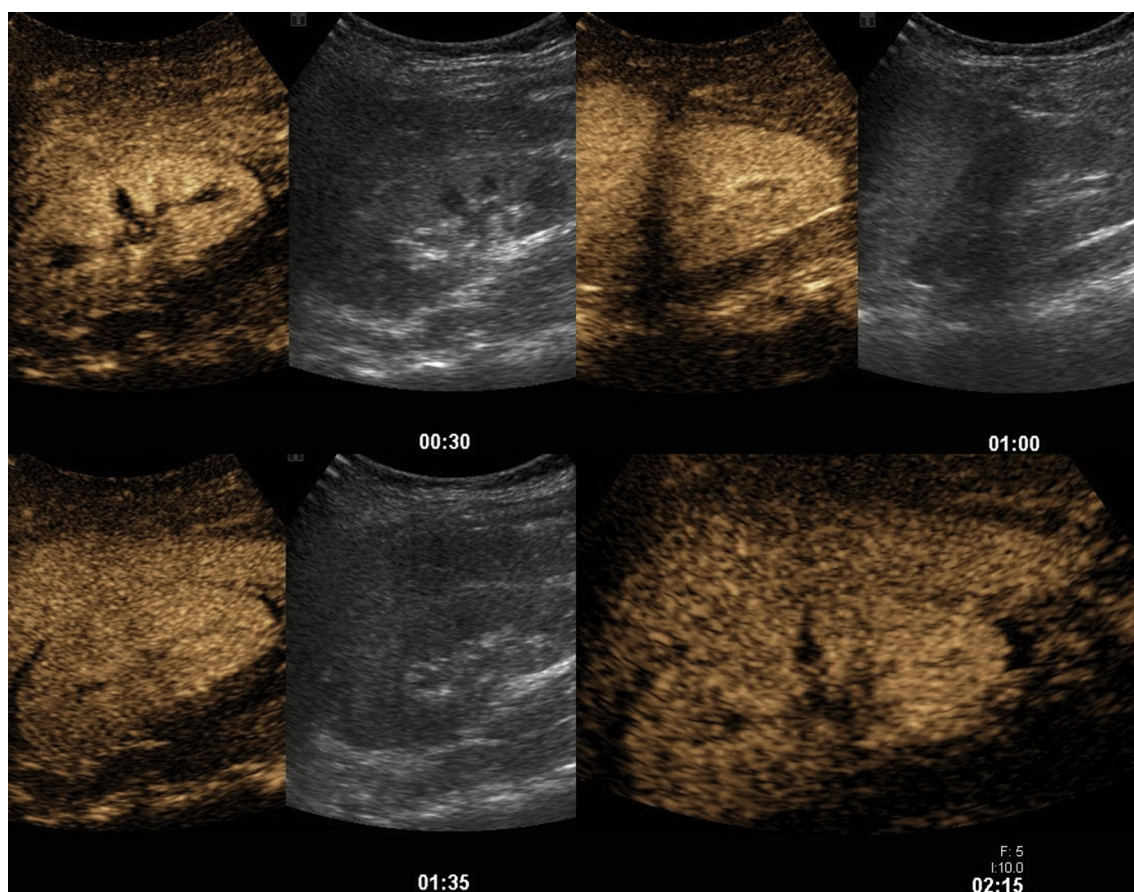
Renal perfusion. Post-contrast-enhanced ultrasound shows prompt homogeneous uniform enhancement of both kidneys, with no perfusion defects or areas of ischemia/necrosis. These images excluded the possibility of a thromboembolic episode within the kidney and shows that the renal arteries were patent.
